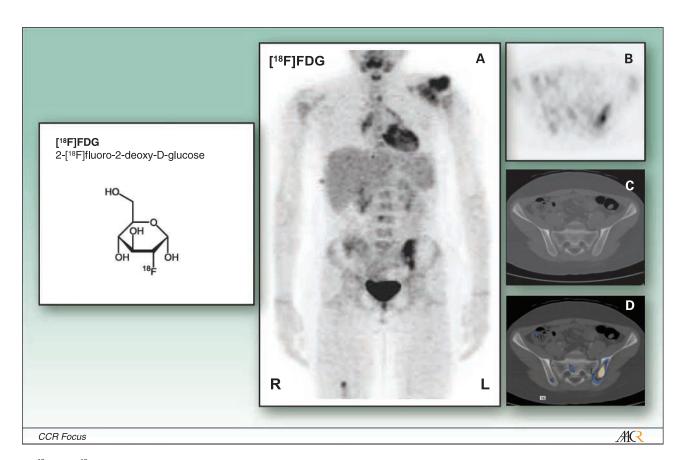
[18F]FDG. [18F]FDG-PET/CT of a patient with Ewing's sarcoma. The primary tumor is located in the left shoulder region. Intense uptake of FDG can be detected in the primary tumor as well as in multiple bone metastases. *A,* maximum intensity projection of [18F]FDG-PET. *B,* transaxial section of [18F]FDG-PET through the pelvis. *C,* corresponding transaxial section of CT. *D,* fused image ([18F]FDG-PET/CT). Transaxial sections indicate a bone metastasis in the left iliac bone not visible on the corresponding CT section.
